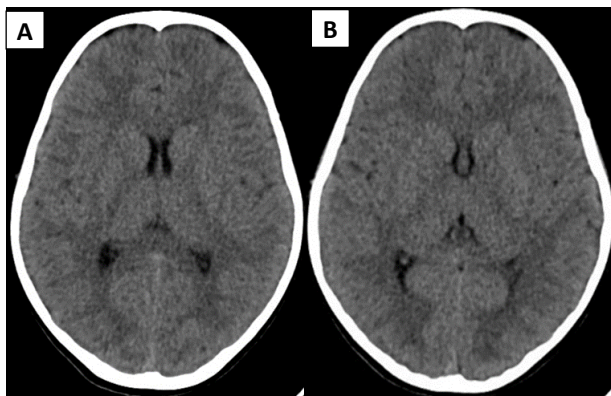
Axial CT brain image of the 3-year-old patient taken using (A) standard pediatric brain protocol (B) low dose pediatric brain protocol.
